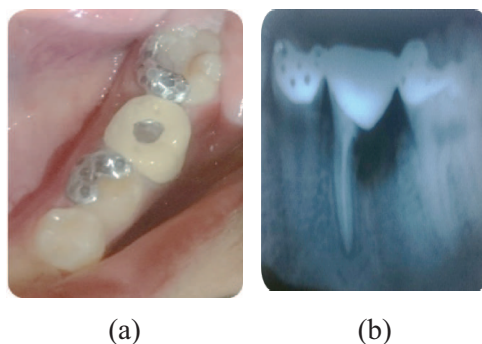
(a) The insertion of resin bonded rochette bridge type with occlusal metal; (b) post operative radiograph.
